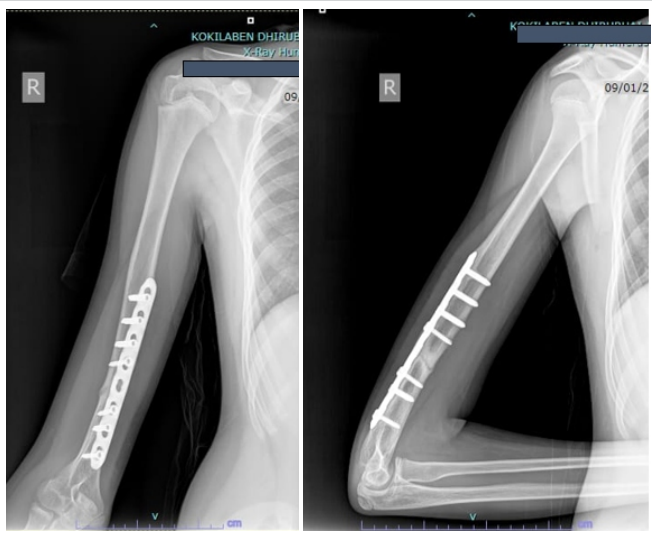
Radiograph at 7 months showing non-union.
